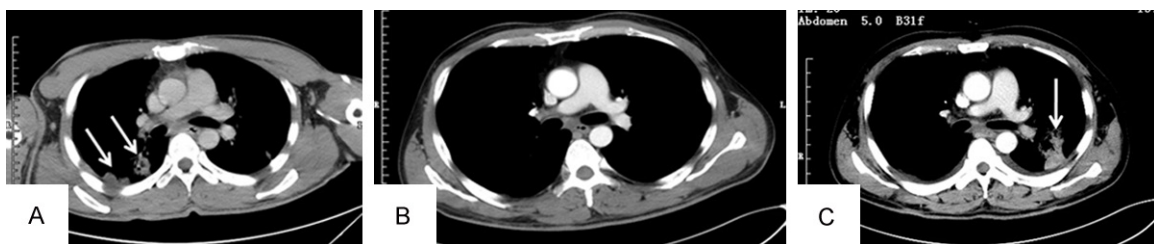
CT showed metastases (white arrows) in the lungs. A: Before the chemotherapy; B: After two courses of chemotherapy; C: Nearly three months after the chemotherapy.
